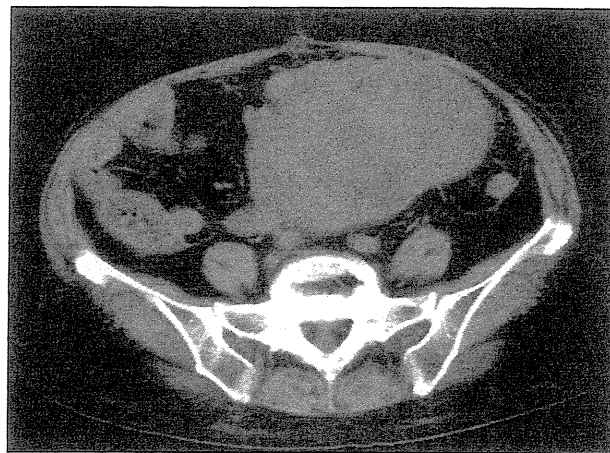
Abdominal CT scan shows a large tumor.
